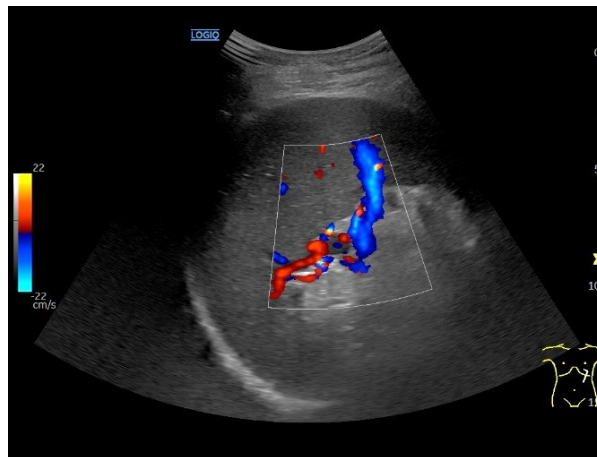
Color Doppler ultrasound of the spleen hilum, showing normal splenic vasculature with appropriate arterial and venous flow dynamics.
